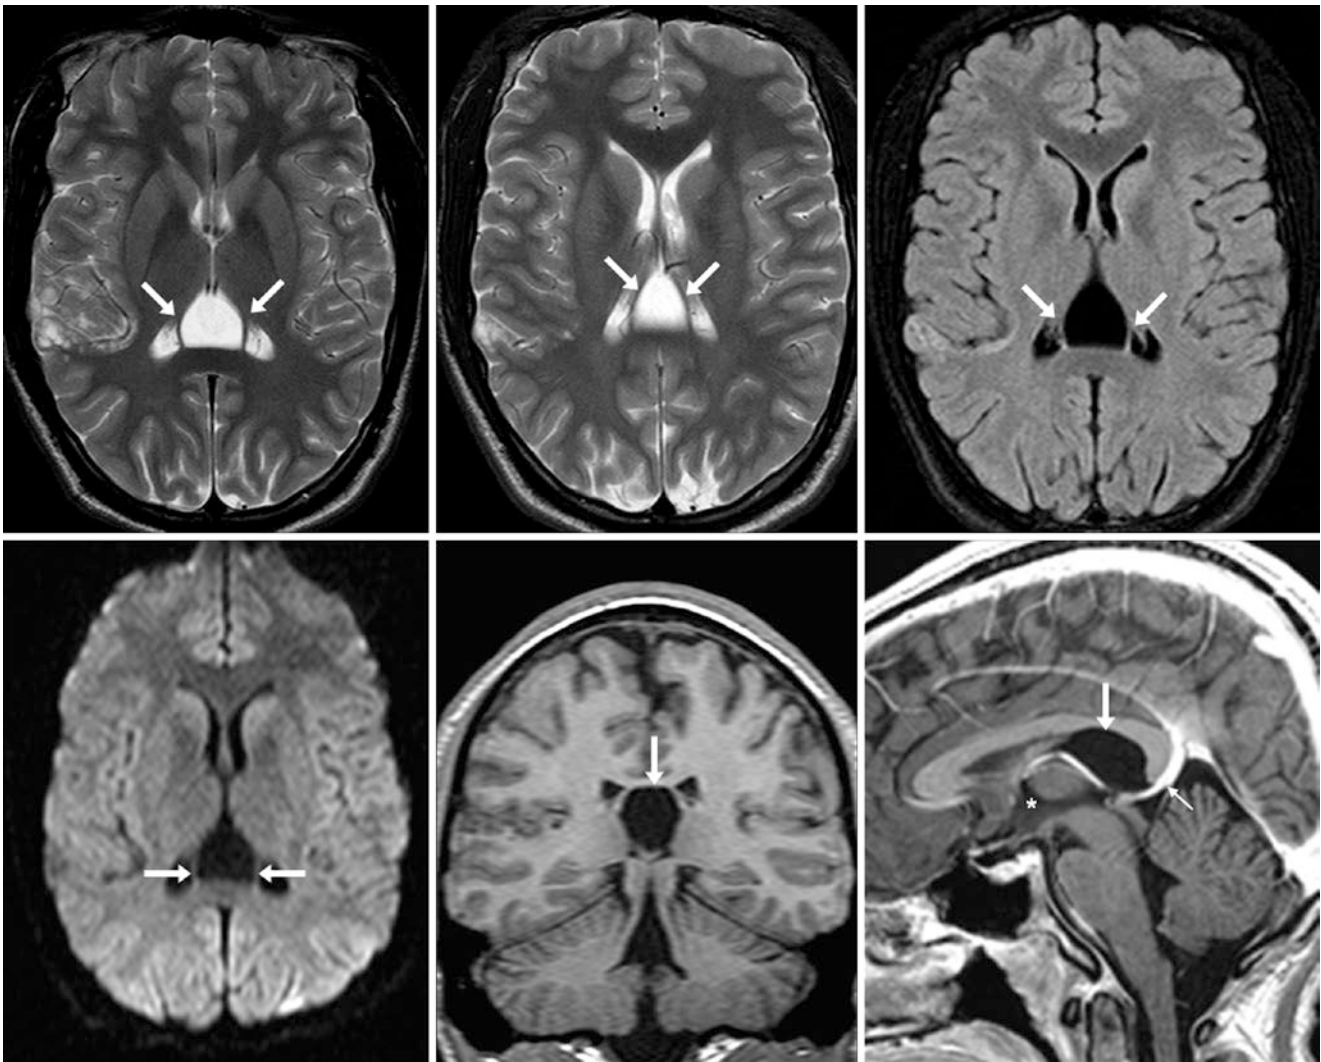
A 20 year old with a CVI (arrows) shown on MRI T2WI (top left and top middle), FLAIR (top right), DWI (bottom left), coronal T1WI (bottom middle), and postcontrast sagittal T1WI (bottom right). Note an internal cerebral vein (tiny arrow) coursing along the floor of the CVI and that the pineal region is not involved. Also, note the third ventricle (*)
